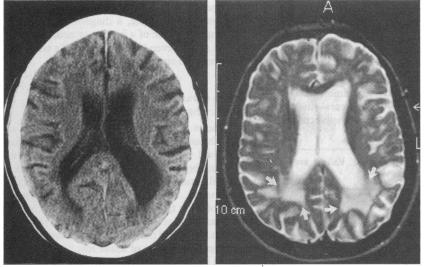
Left: Computed tomogram of brain showing moderate degree of low attenuation of white matter. Right: Magnetic resonance image of brain of same patient showing more extensive white matter hyperintensities (arrows)
